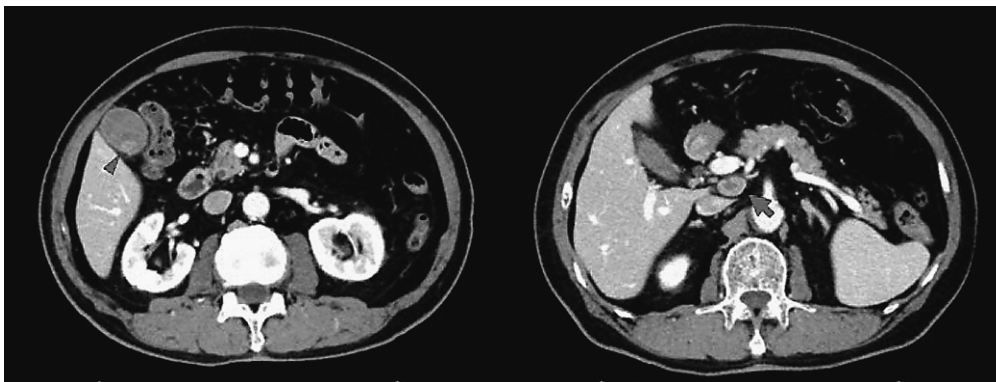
Abdominal computed tomography showing a polypoid nodule on the gallbladder wall (arrowhead) and an enlarged regional lymph node with internal necrosis (arrow).
